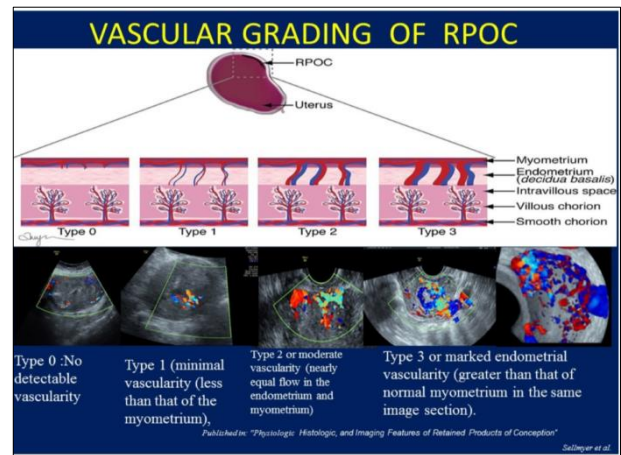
Vascular grading of retained products of conception on ultrasound and colour Doppler.¹
